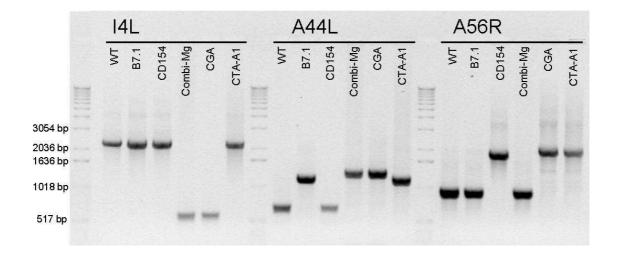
Characterization of recombinant viruses: PCR amplification of loci I4L, A44L and A56R. Genomic DNA of VV $_{WT}$  (WT), rVV $_{B7.1}$  (B7.1), rVV $_{CD154}$  (CD154), rVV $_{combi-MAGE}$  (Combi-Mg), rVV $_{CGA}$  (CGA) and rVV $_{CTA-A1}$  (CTA-A1) was amplified using primers for flanking regions of each insert and analysed in a 1% agarose gel. 1Kb ladder.
